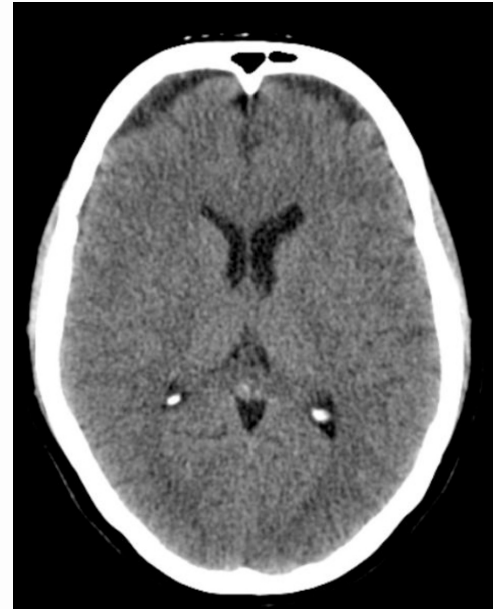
Example of a similar CT scan of our patient.²
